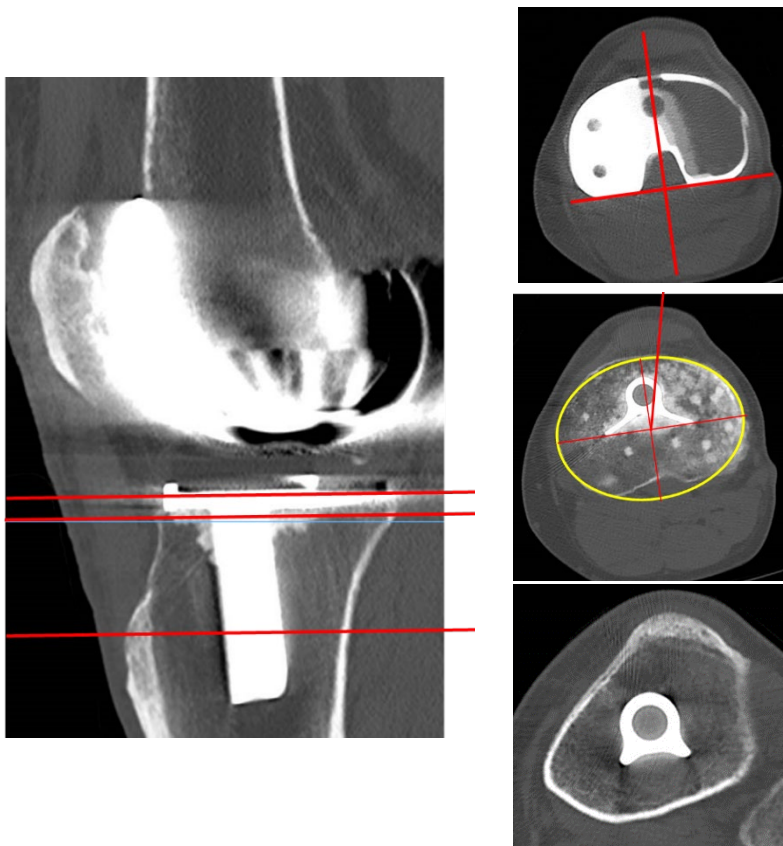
Rotational alignment of the tibial component was measured on three axial CT scans. One at the level of the tibial tuberosity, the second through the tibial plateau just beneath the tibial base-plate, and the third through the tibial base-plate. Refer to the text for more detailed description.
